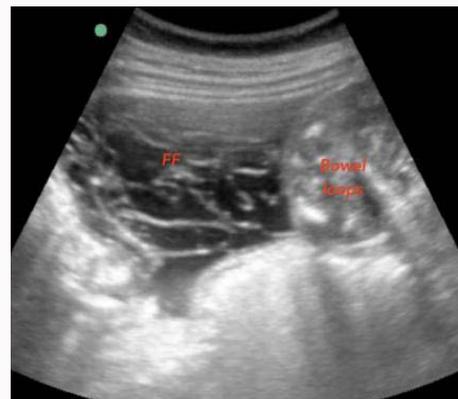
Transabdominal ultrasound of the right upper quadrant showing complex free fluid with lacelike internal echoes and bowel loops (FF: Free Fluid).
